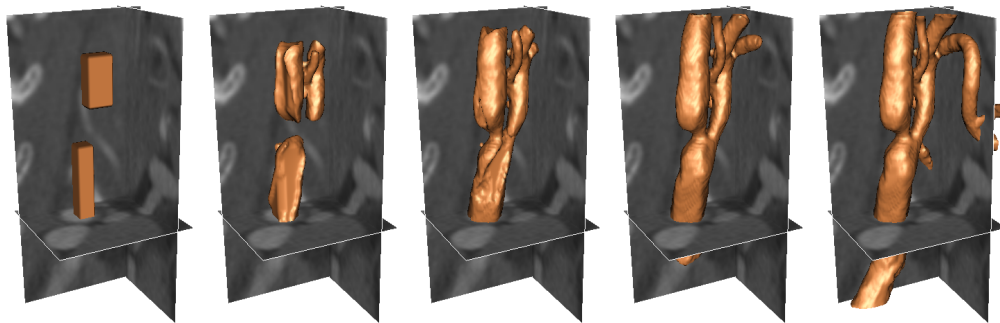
Segmentation of carotid artery from CT image dataset 5 (70x80x120) using GPF deformable model (CPU-time, 1379s).
